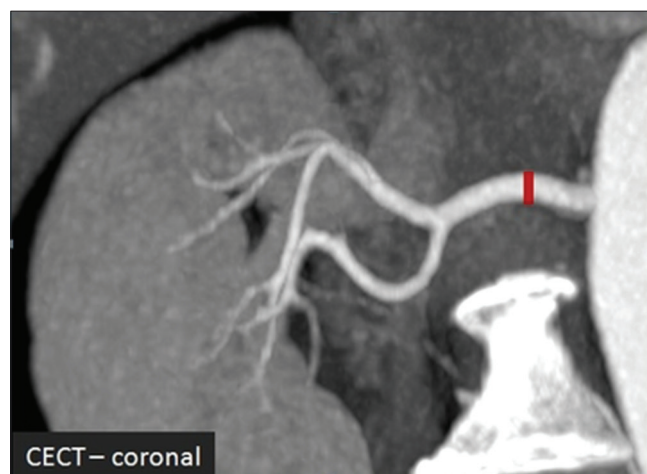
Computed tomographic angiography coronal image showing the method of measuring postostial segment of the main renal artery
